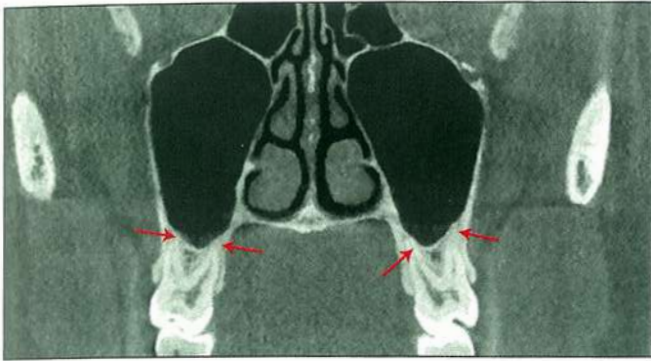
A coronal section of the maxillary sinus using cone beam computed tomography (CBCT) imaging. Note the close proximity of the root tips to the floor of the sinus (*red arrows*).
